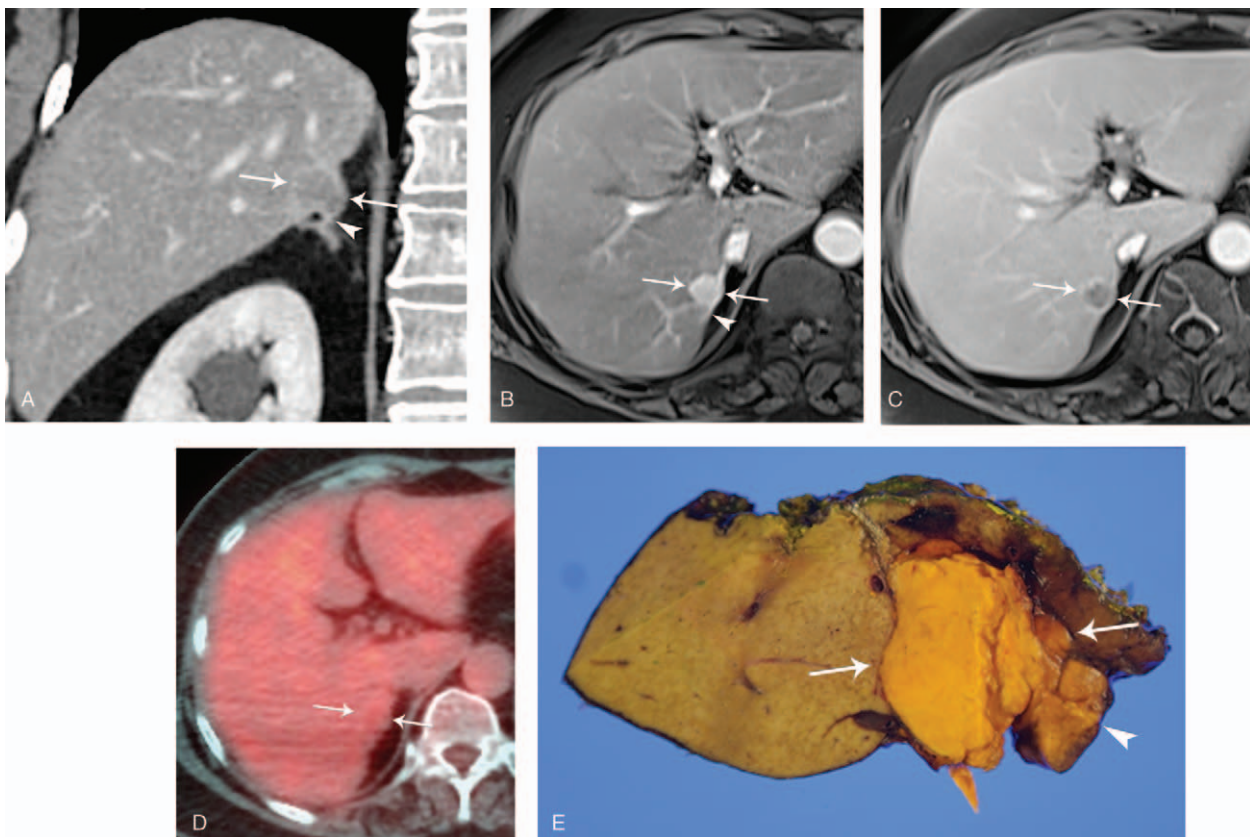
A 1.5-cm intrahepatic adrenocortical adenoma in a 59-year-old woman that was pathologically confirmed through the right posterior sectionectomy. (A) Contrast-enhanced coronal portal phase CT image clearly shows the connection (arrowhead) between the tumor (arrows) and lateral limb of right adrenal gland, which implies the tumor arising from adrenohepatic fusion. (B and C) Gadoxetic acid-enhanced MR images demonstrate hyper-arterial enhancement and delayed washout of a round subcapsular tumor (arrows), such as the typical enhancement pattern of hepatocellular carcinoma, in the right hepatic lobe. Note the arterial enhancing linear lateral limb (arrowhead) in the right adrenal gland, which is continuous with the tumor on B. (D) ¹⁸F-FDG-PET/CT image depicts the ¹⁸F-FDG uptake of the tumor (arrows) similar to the physiologic uptake of the liver parenchyma, which suggests low likelihood of malignancy. (E) Photograph demonstrates a 1.5-cm yellowish subcapsular tumor (arrows) of the resected liver, which is connected to the right adrenal gland (arrowhead).
